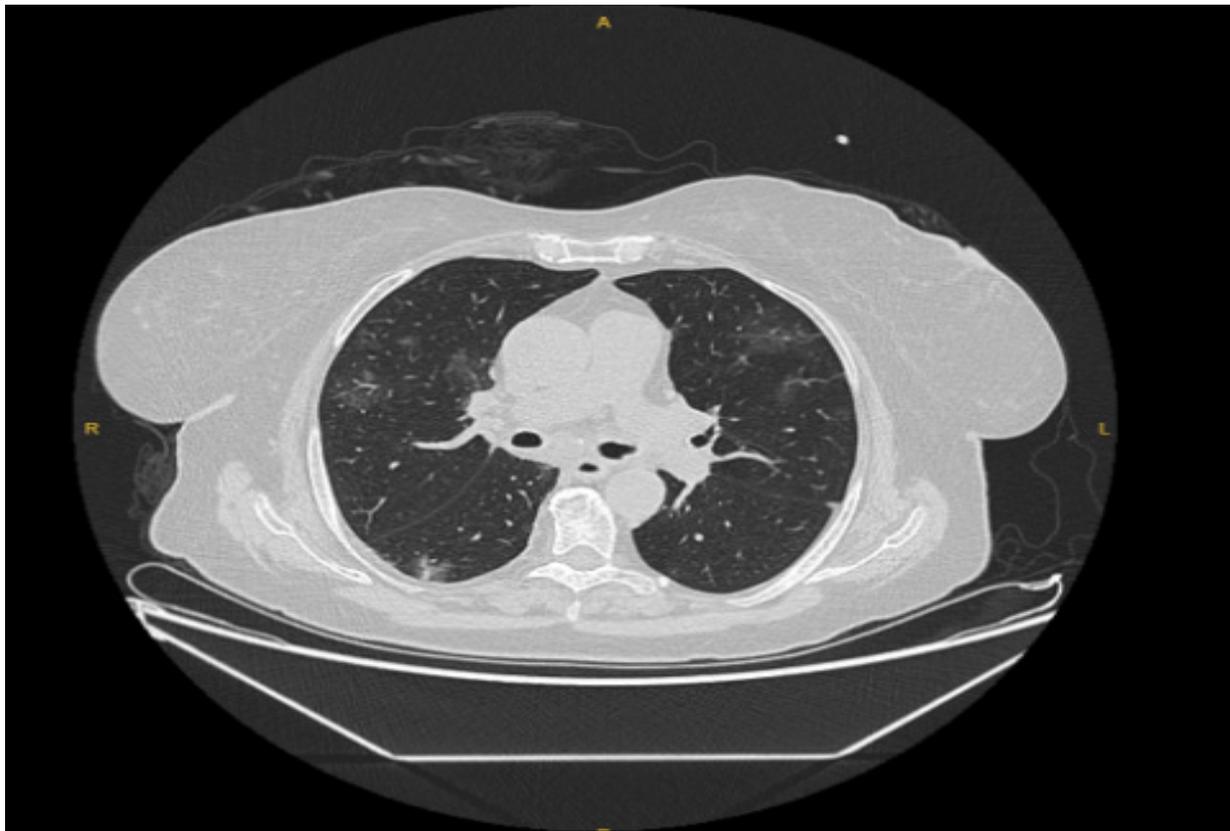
Bilateral subpleural ground-glass opacity lesions observed on computed tomography.
